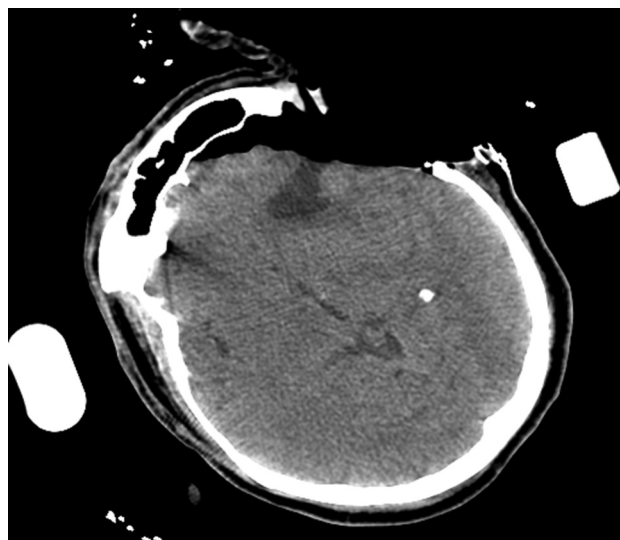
Case 1. Intraoperative computed tomography scan showing subtotal tumor removal.
